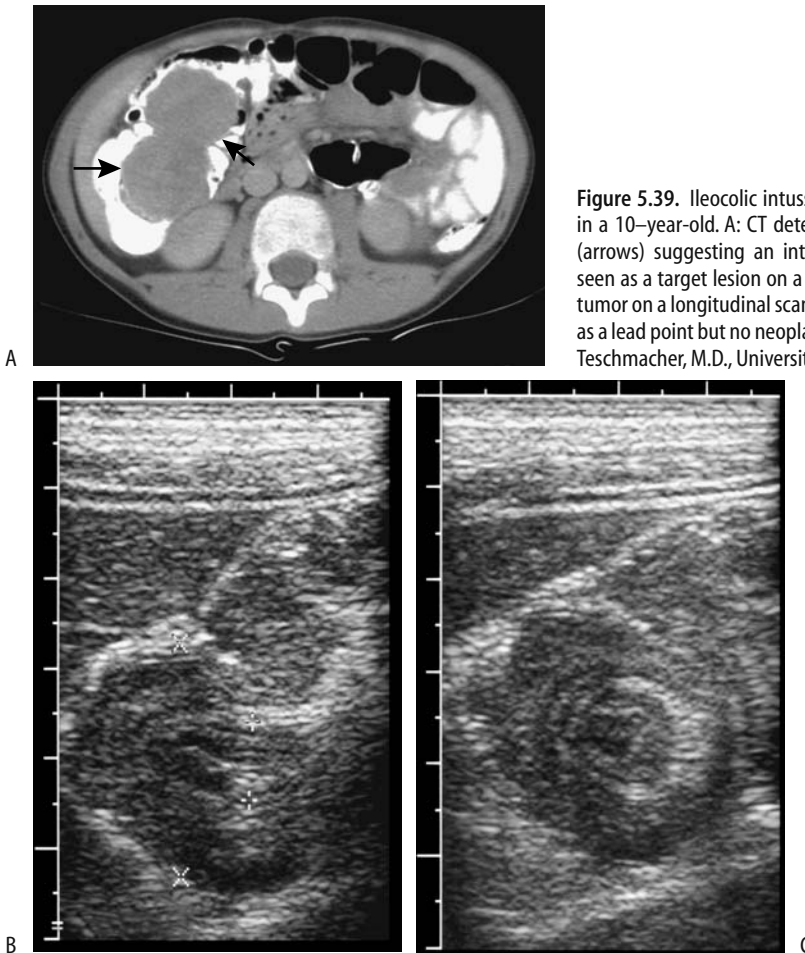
Ileocolic intussusception due to large lymph nodes in a 10-year-old. A: CT detects an intraluminal right colic tumor (arrows) suggesting an intussusception. The intussusceptum is seen as a target lesion on a transverse US scan (B) and as an oval tumor on a longitudinal scan (C). Surgery revealed enlarged nodes as a lead point but no neoplasm was identified. (Courtesy of Luann Teschmacher, M.D., University of Rochester.)
